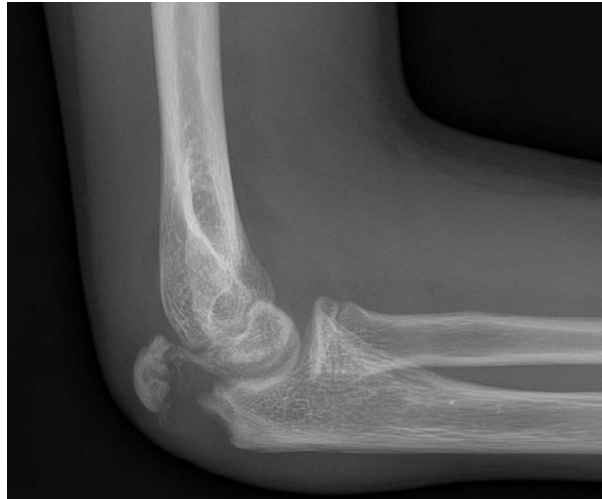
Lateral radiographic view of the right elbow in a patient with osteogenesis imperfecta, demonstrating an olecranon apophyseal fracture.
